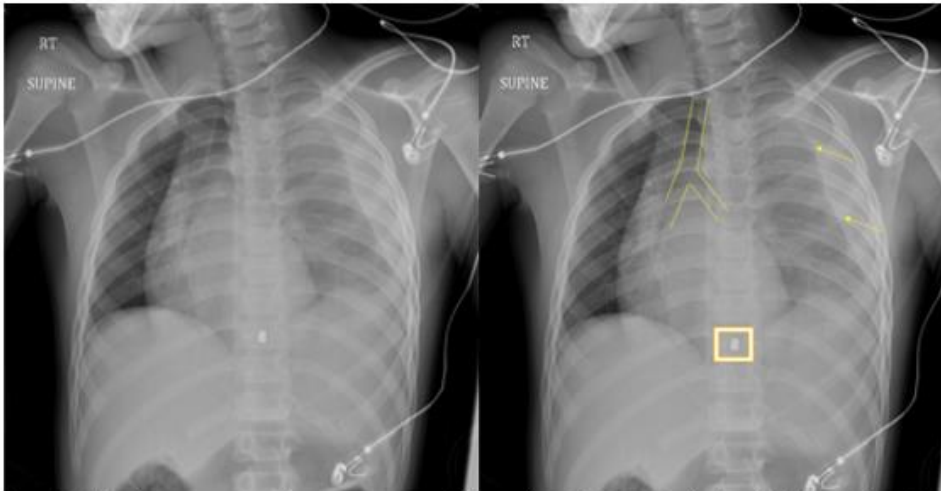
Initial emergency department radiography Fig 2: Medistinal shift outlined; radiopaque pellet, square
